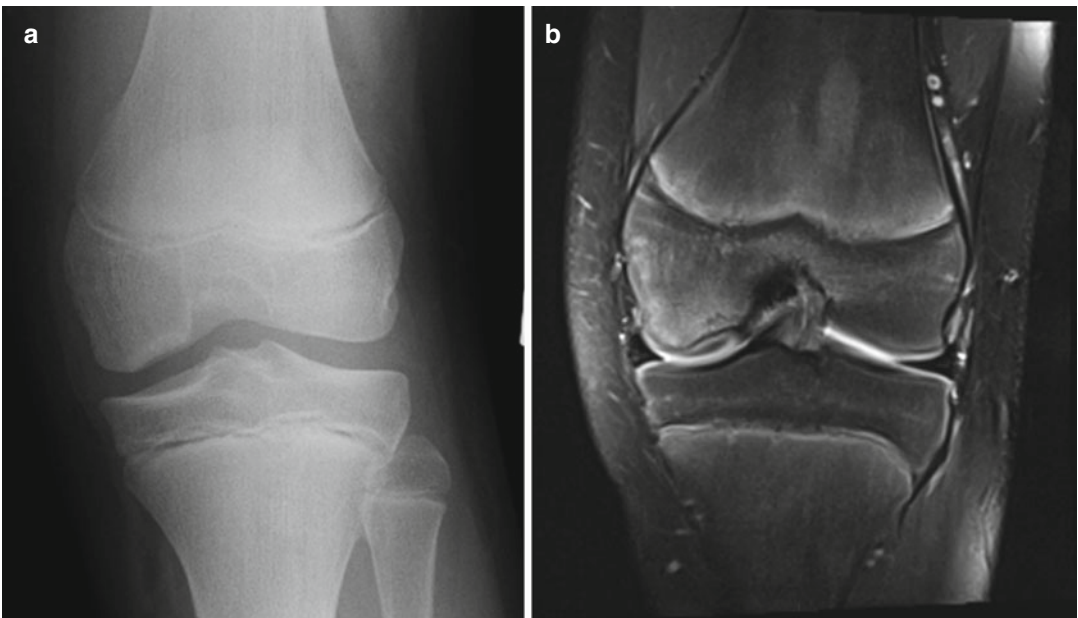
Juvenile type of OCD of the medial femoral condyle (a). The MRI shows that the articular cartilage overlying the lesion is intact (b)
